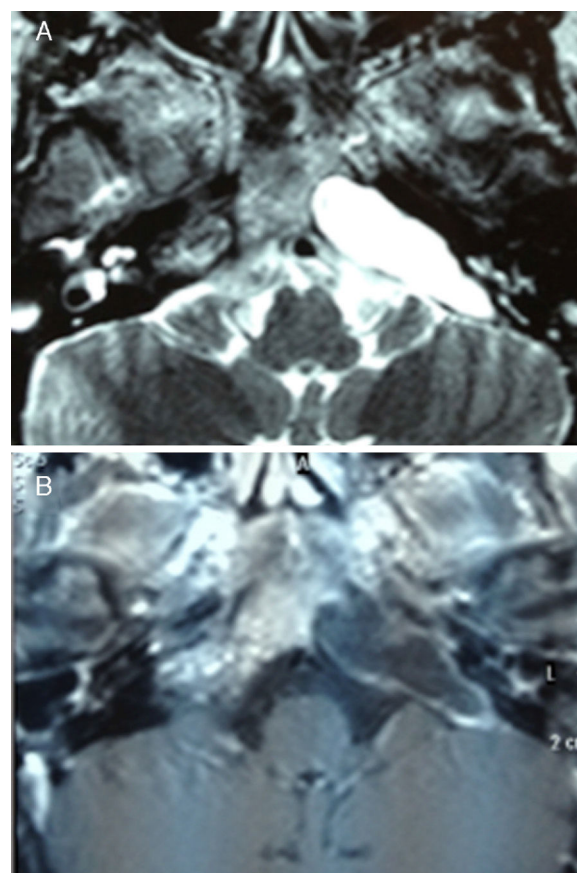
MRI of the brain, epidermoid tumour of the petrous apex with involvement of the clivus. (A) Axial section of T2 hyperintense tumour. (B) Axial section in T1. Hyperintense tumour with inner mottled areas suggestive of epidermoid tumour.
